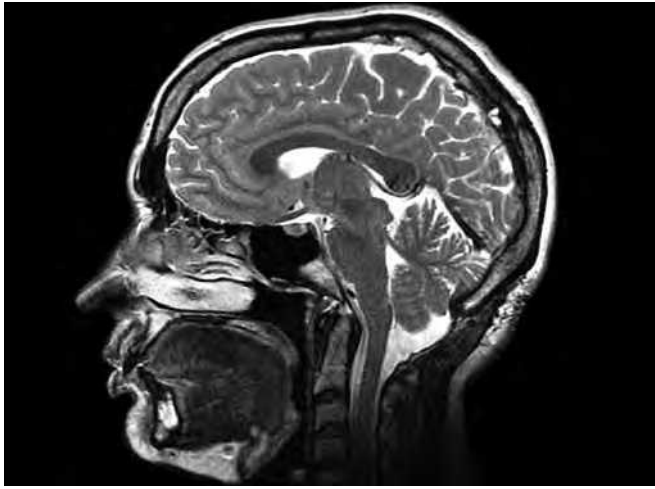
Sagittal magnetic resonance imaging demonstrating decompression of posterior fossa and foramen magnum.
